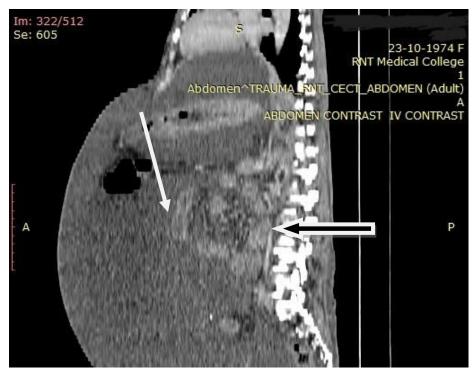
Shows sagittal contrast enhanced CT images in which the black arrow denotes clumped small bowel loops and the white arrow demarcates the thickened enhancing membrane of sclerosing encapsulating peritonitis.
